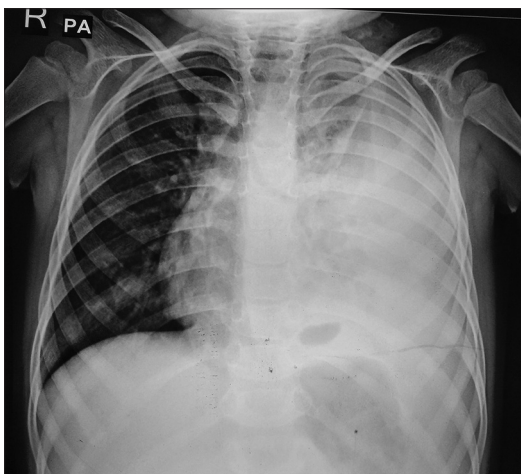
X-ray chest posteroanterior view showing homogenous opacity involving the entire left hemithorax with sparing of the upper zone of the left lung with large pleural effusion and mediastinal displacement
